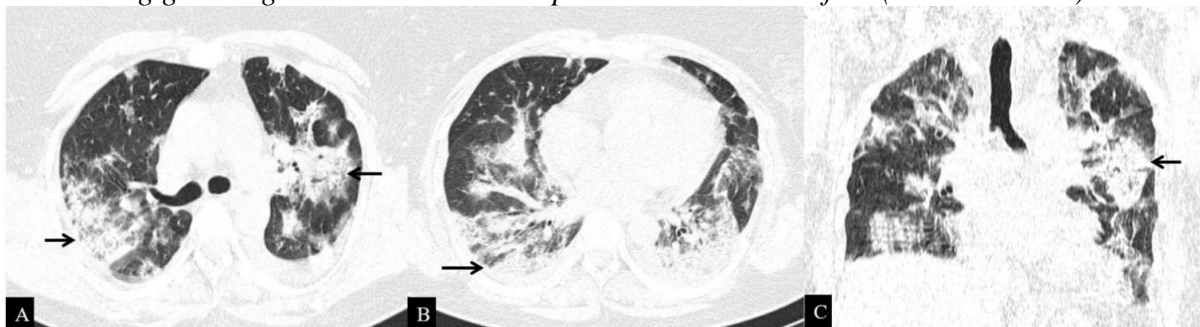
(A-C): Axial (A-B) and coronal (C) non-contrast CT scan images in lung window of a 56-year-old unvaccinated male show diffuse areas of ground glass attenuation with interlobular septal thickening in bilateral lungs predominantly in the lower lobes (blue arrows) along with few patchy areas of consolidation (black arrow). The patient had a CTSS of 25 (severe disease).
